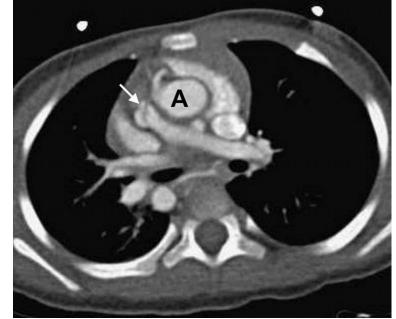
CT axial image of the great vessels shows (A) Aorta leftward to the main pulmonary trunk (white arrow). According to the loop rule, she would have L-loop ventricular orientation.
